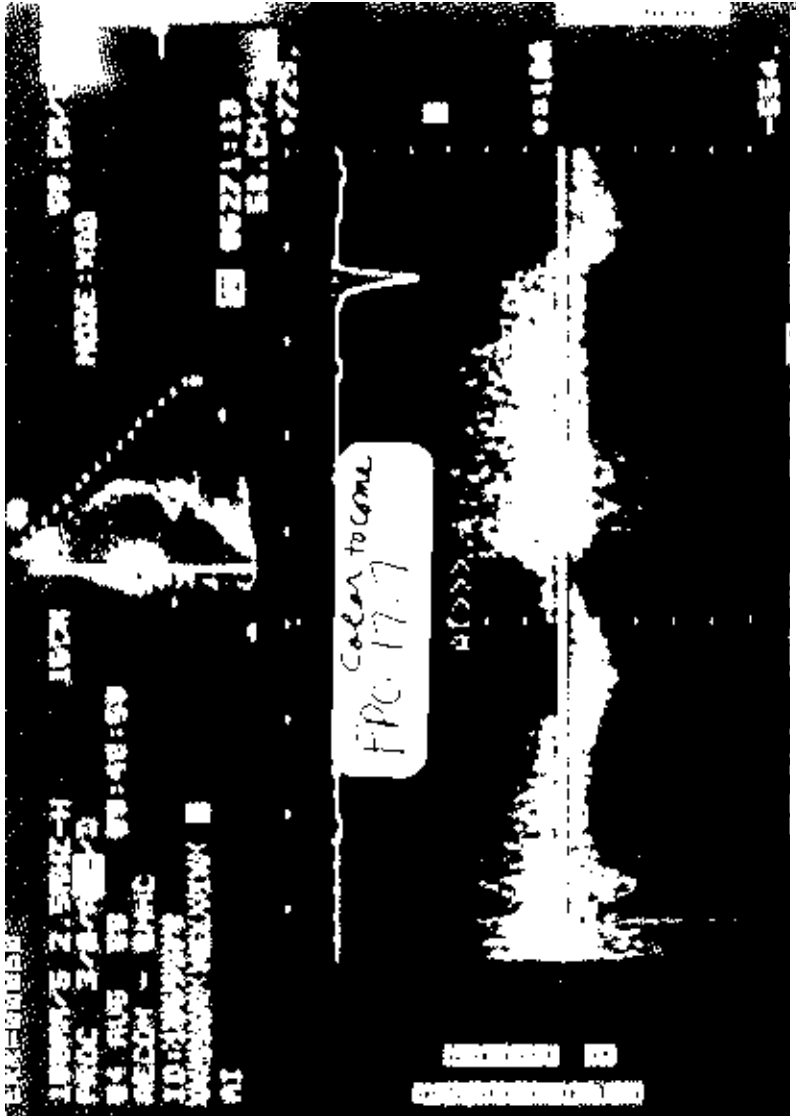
Continuous-wave Doppler recording of the velocity profile across the aortic valve in the same patient shown in Figure 6. A holosystolic decrescendo high-velocity profile is recorded from the left ventricular outflow tract, characteristic of aortic insufficiency. AI = aortic insufficiency.
